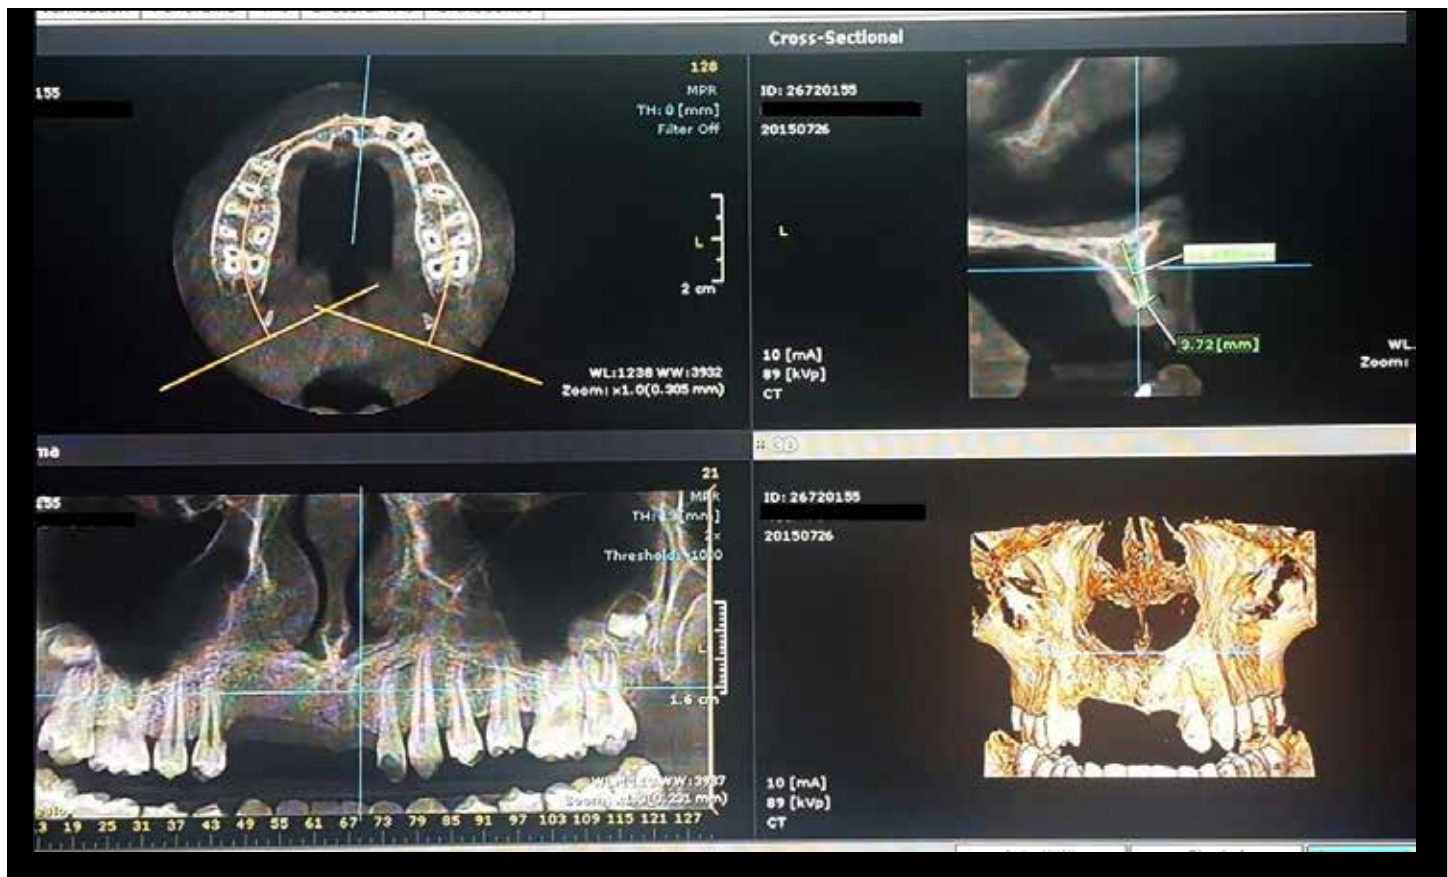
Preoperative CBCT showing the deficient maxillary alveolar ridge width measurements.
